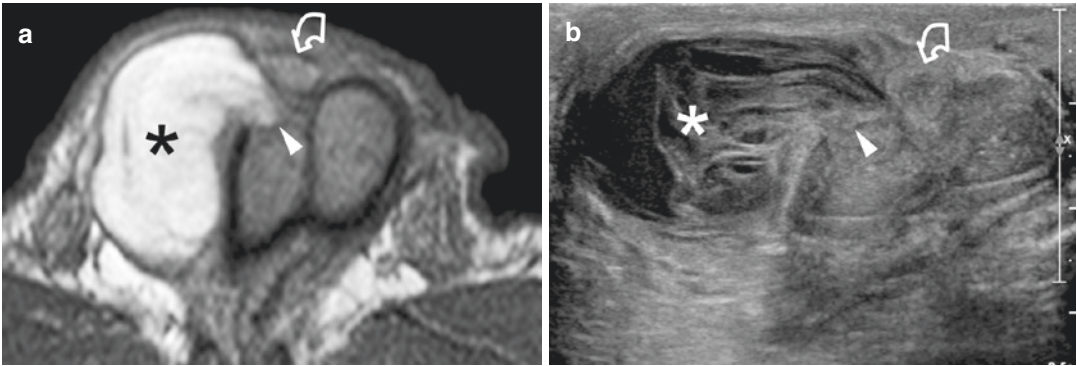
Penile fracture of the right corpus cavernosum. (a) Axial T2-weighted scan shows the lesion as a ventral interruption (*arrowhead*) of the low-signal-intensity tunica albuginea. There is an associated extraalbugineal haematoma (*asterisk*). The left corpus cavernosum is intact. (b) Corresponding ultrasonographic scan showing
